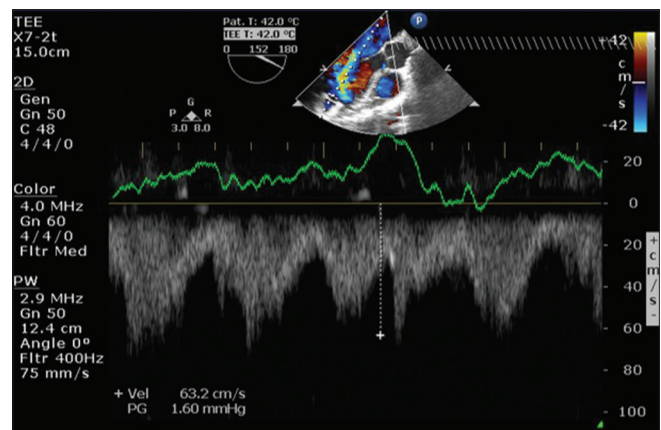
Doppler sampling at the inflow cannula, with normal flow velocities
